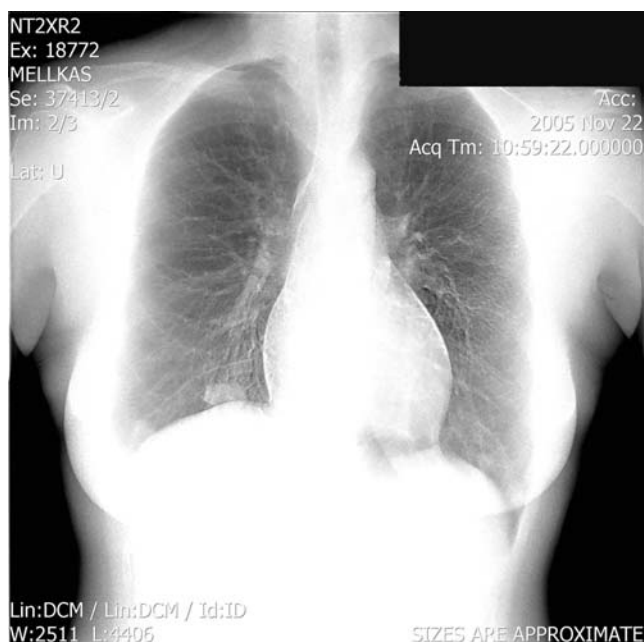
Multiple rheumatoid nodules in the right lower lobe of the lung, near the diaphragmal surface (chest X-ray)
